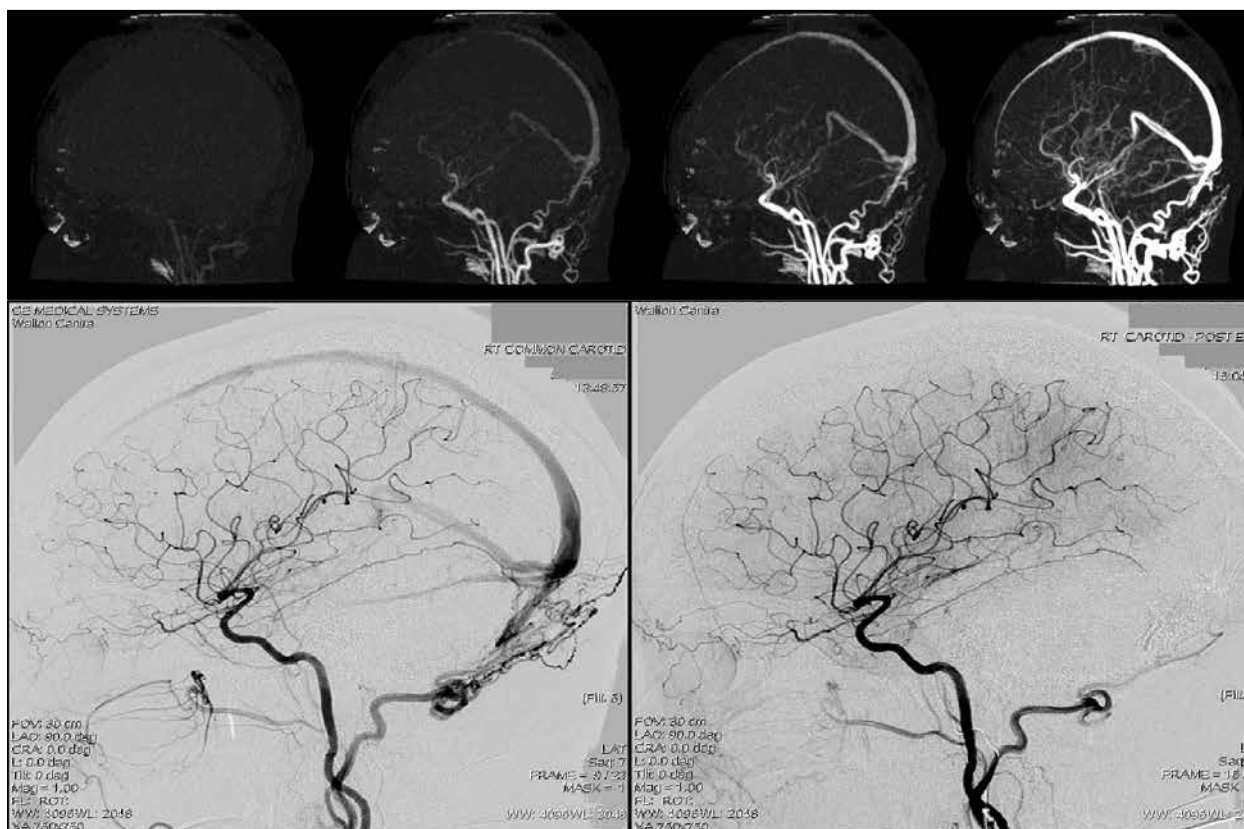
Top images: 4D computed tomography angiography showing sequential images with simultaneous contrast filling of the intracranial arteries and the sagittal and transverse sinuses, suggestive of an arteriovenous connection.
